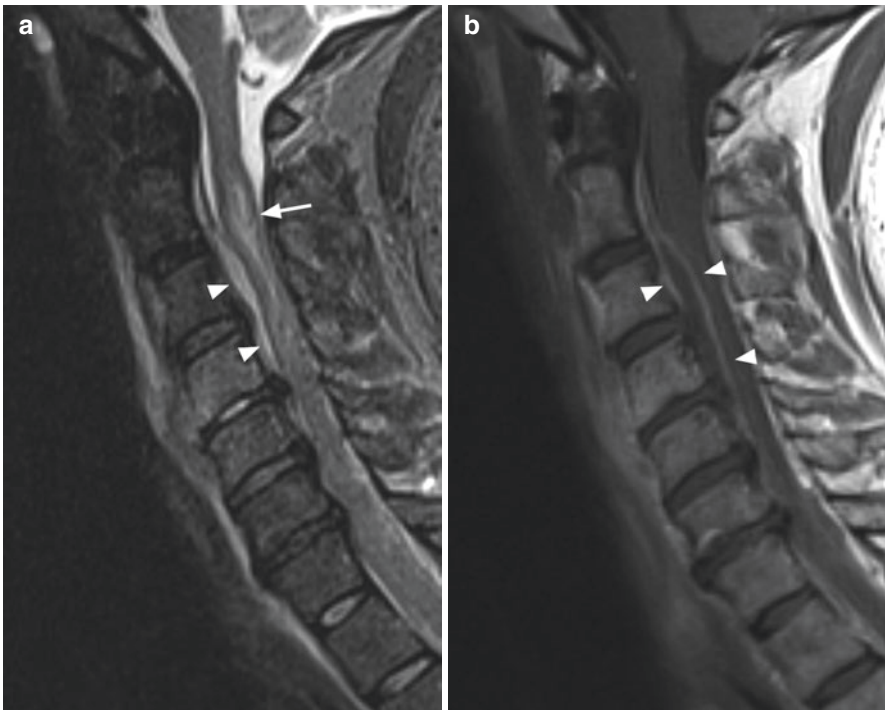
(a) Findings of cervical spondylodiscitis associated prevertebral and epidural extension on STIR MRI. Arrowheads delineate epidural collection causing cord compression with marked cord edema, arrow pointing to bright signal in spinal cord. (b) Typical finding of a ventrally located epidural abscess on gadolinium-enhanced T1W MRI. Arrowheads delineating rim enhancement of the abscess
